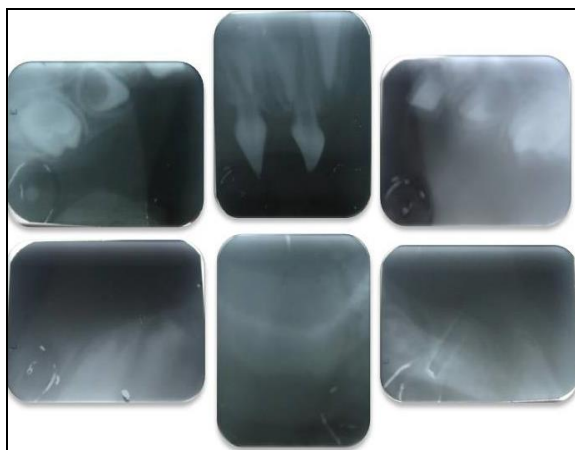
Full month IOPA radiographs of patient
